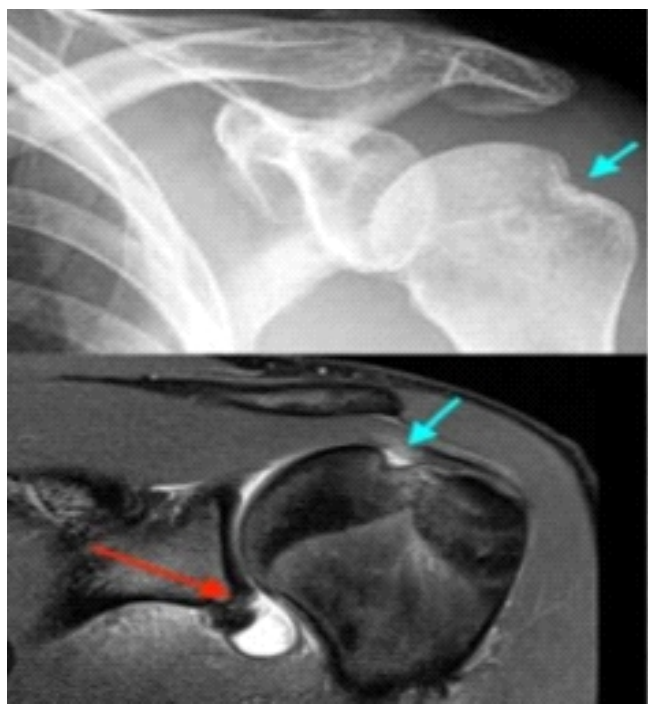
Hill-Sachs's lesion and Bankart's lesion on radiograph and magnetic resonance imaging.
